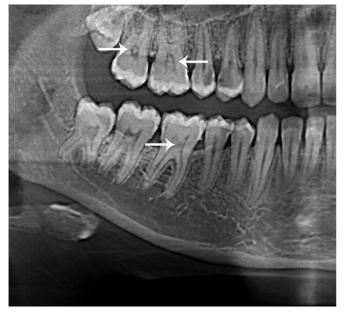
A close-up view of a panoramic radiograph showing idiopathic pulp stones within the coronal pulp chambers of the maxillary right first and second molars and mandibular right first molar (white arrows).
